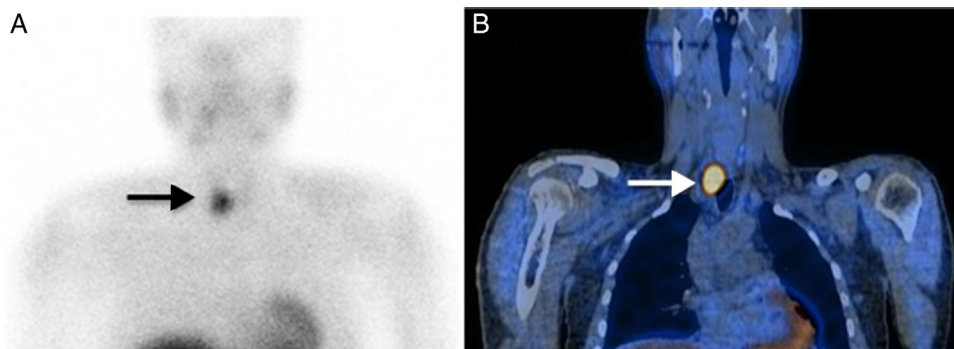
^{99m}Tc MIBI parathyroid scintigraphy planar (A) and SPECT/CT coronal (B) images showed a focus of intense radiopharmaceutical uptake (arrow) just below lower pole of the right thyroid lobe.
